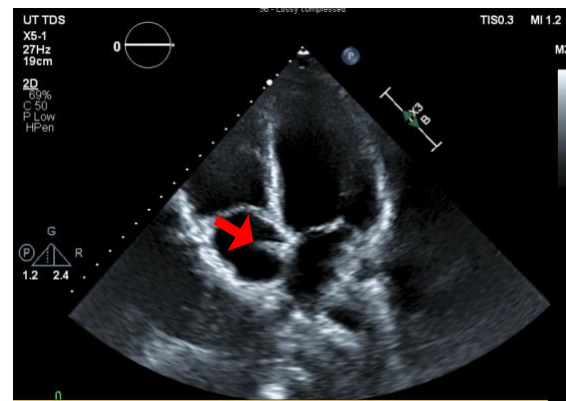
Transthoracic echocardiogram revealing the fibromuscular membrane of the incomplete cor triatriatum dextrum.
